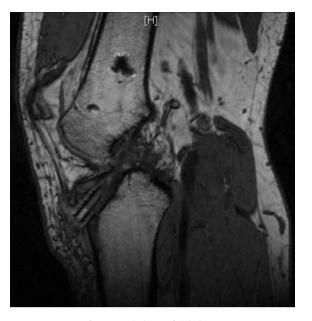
Saggital MRI of right knee.
